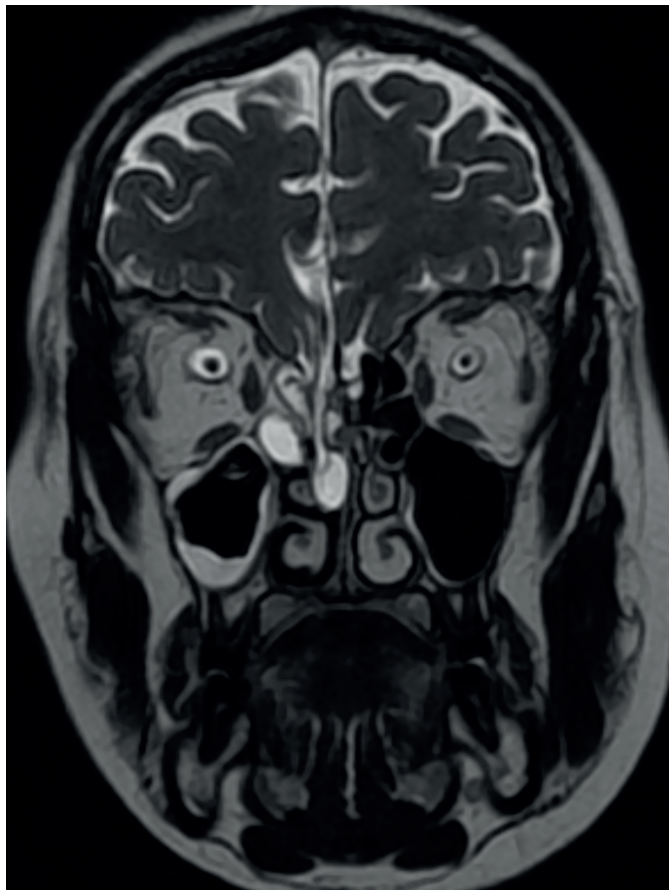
Coronal T2W MRI showing right transcribriform plate intranasal meningocele.
